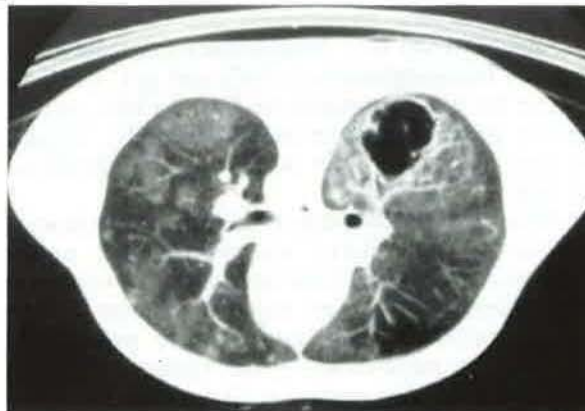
A: Chest radiograph showing thin-walled cavitations on the right middle and left upper pulmonary areas; B: computed tomography scan showing thin-walled cavitations with alveolar and interstitial infiltration.
